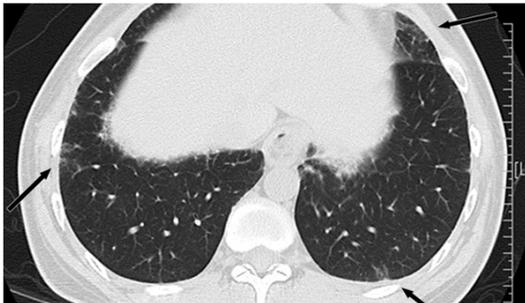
Computed tomography of the chest on a patient with interferon-induced cardiovascular disease. The image was taken on day 7 after the withdrawal of interferon treatment. Arrows indicate peripheral predominant ground-glass opacity with mild reticulation in inferior lingular segment of upper lobe of left lung and the basal segments of lower lobes.
